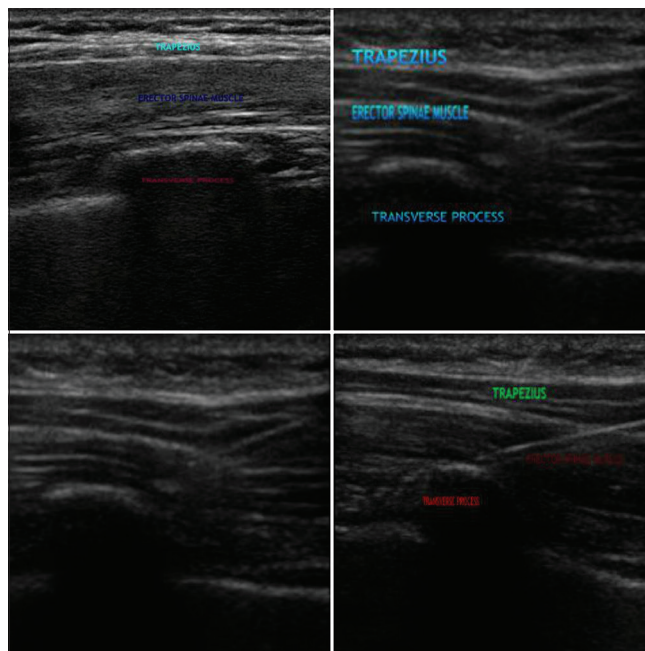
Ultrasonographic image of ESP block
